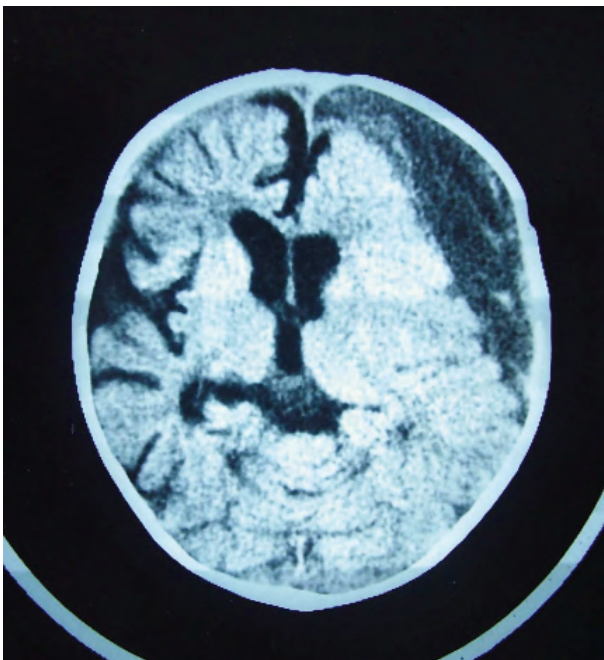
Axial CT scan showing a low density area with membranous structures in the left subdural space of frontoparietal regions with a marked shift of the midline.
